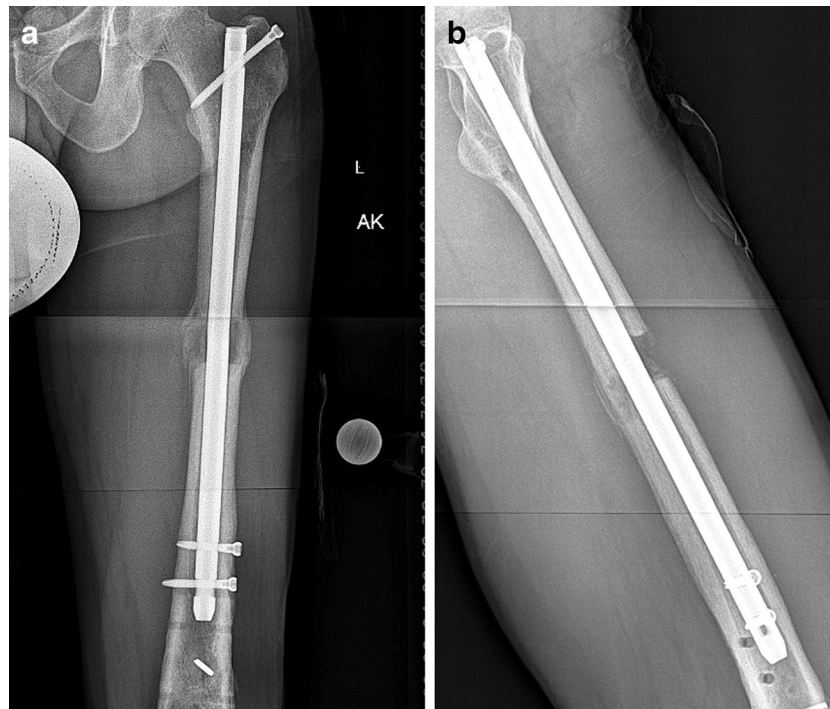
a This AP radiograph of the same case as Figs. 2, 3, and 4, post-distal nail locking and frame removal, shows two cortices of bridging callus. b The lateral X-ray of the same patient shows bridging callus posteriorly but not anteriorly. With bony bridging on the posterior, medial, and lateral cortices, this patient is considered united.
